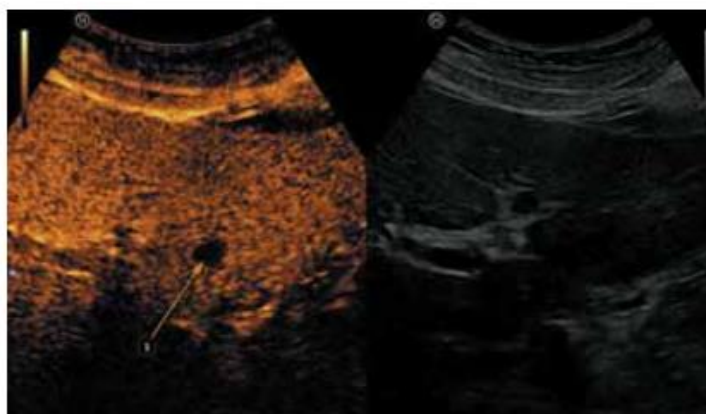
Ultrasound tomogram of the liver with contrast-enhanced ultrasound examination: at the 6th minute (late phase), an anechoic focus is detected in segment II (indicated by an arrow)
